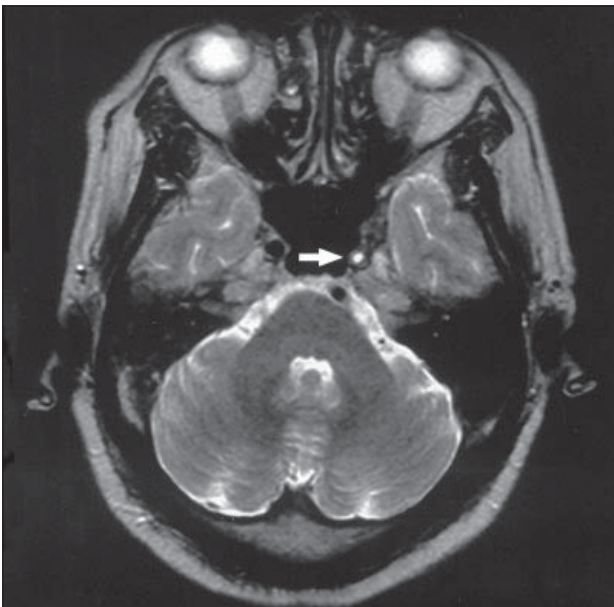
Axial magnetic resonance image of the brain (4000/90) shows hyperintense signal at the cavernous part of the left internal carotid artery (arrow).
